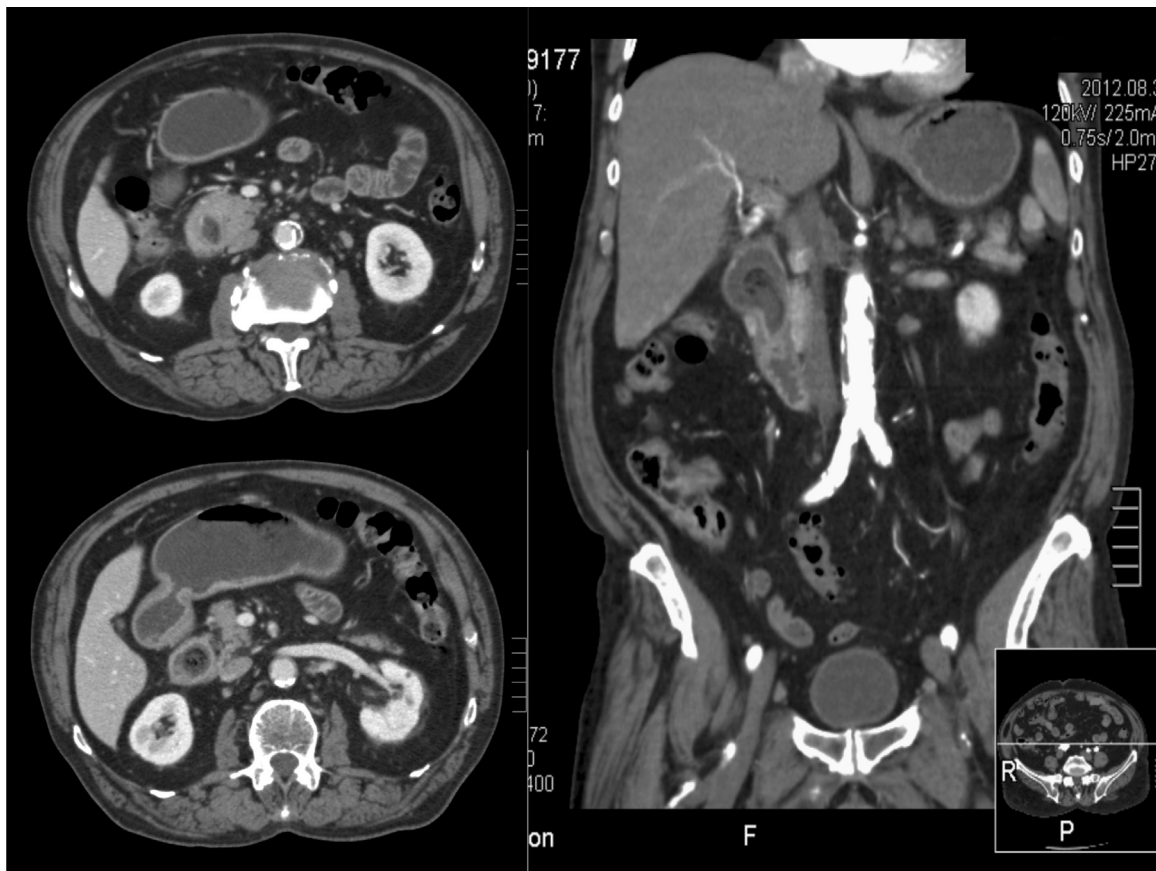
Contrast enhanced CT shows annular pancreatic tissue surrounding the II and proximal III portion of the duodenum with obstructive findings.
